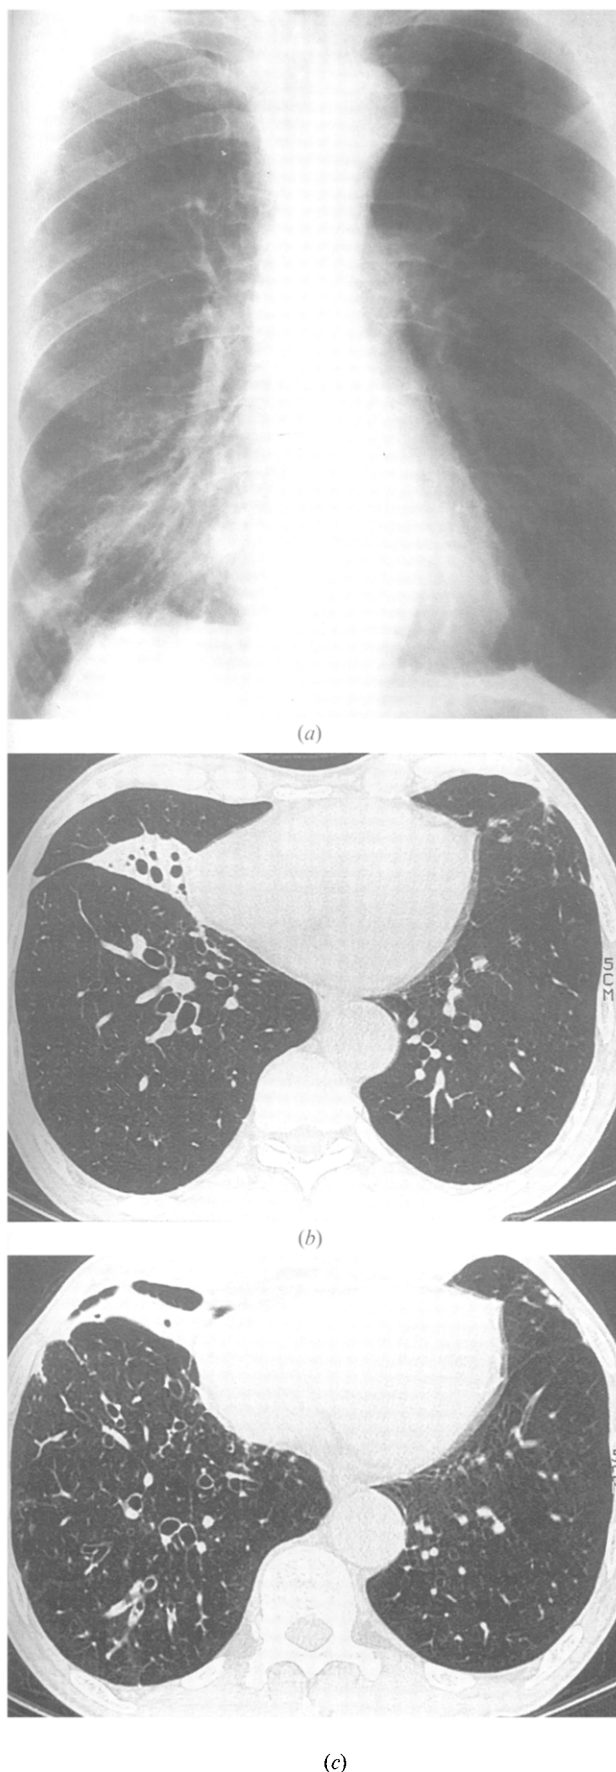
A 77-year-old male with haemoptysis. (No history of recurrent sputum production to suggest bronchiectasis.) (a) Chest radiograph reveals patchy shadowing and slight loss of volume of the right lower lobe. (b,c) HRCT reveals extensive bronchiectasis in the right middle lobe, right lower lobe and to a lesser extent, the lingular segment of the left upper lobe. The right middle lobe is markedly reduced in volume.
